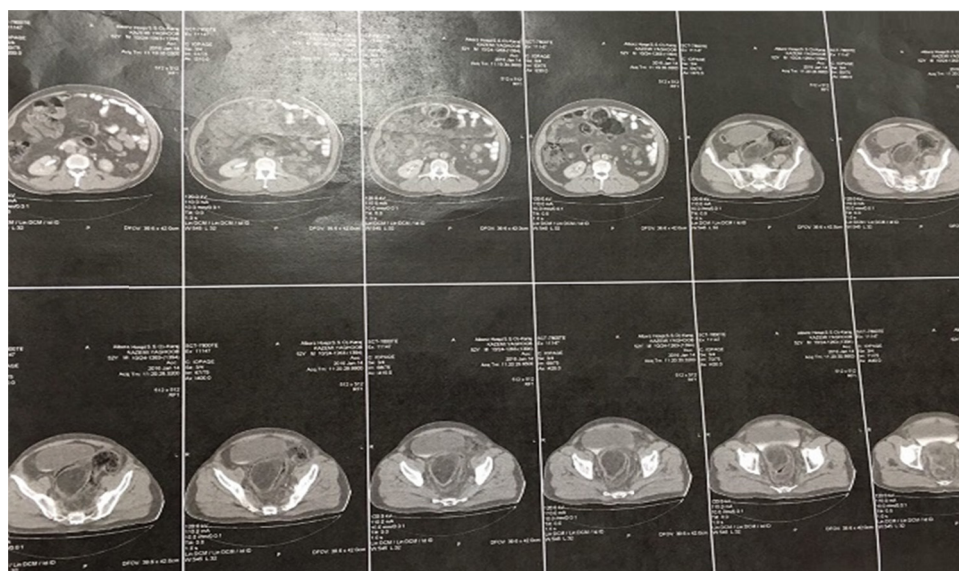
Spiral abdomino-pelvic CT-Scan.
